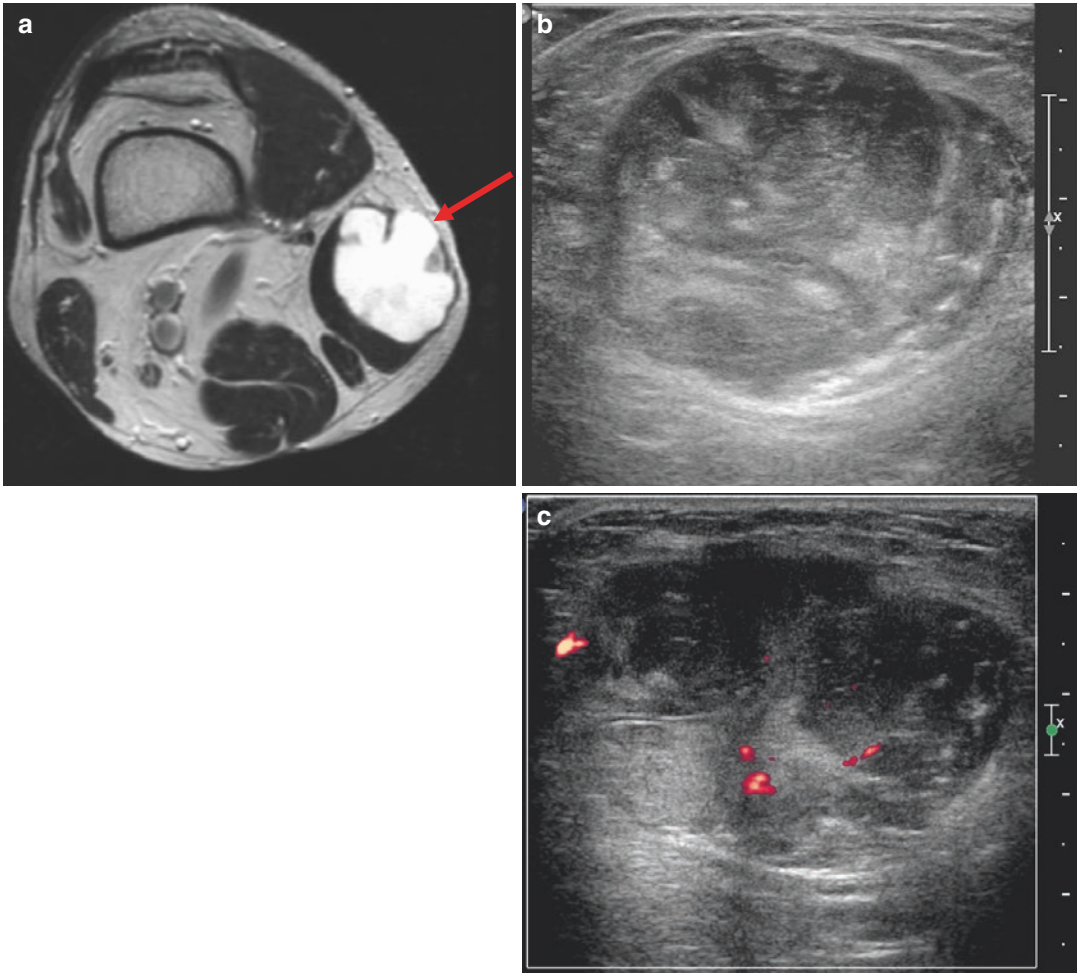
Myxoid liposarcoma. Axial T2WI (a) shows a subfascial mass (*arrow*) of the right sartorius. The mass has a very high signal, which may suggest a cystic or myxoid nature. Transverse US (b) and power Doppler US
